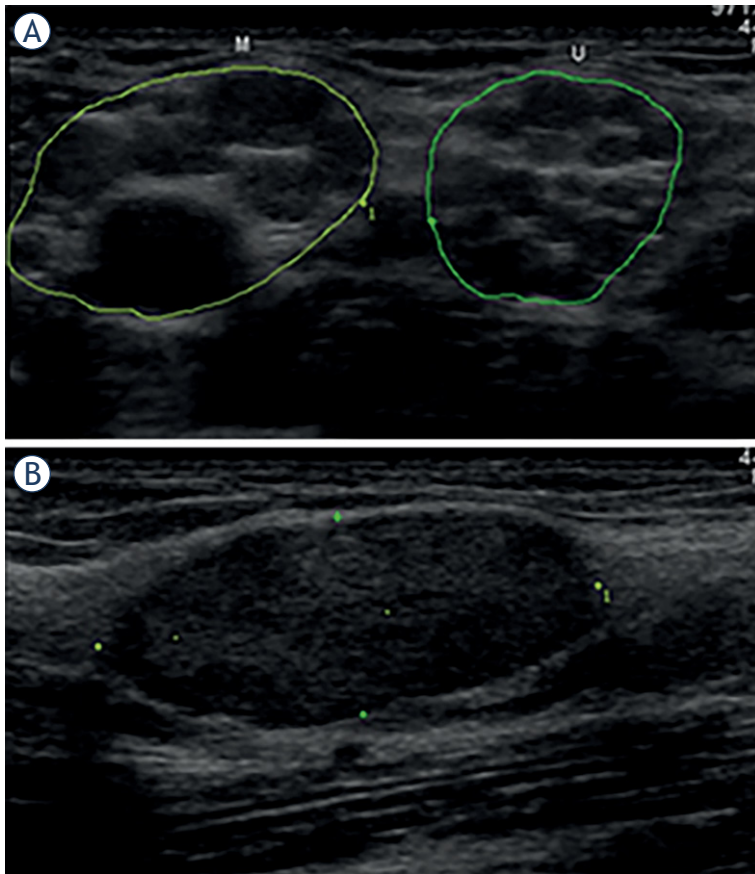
(A) Transverse ultrasonographic (US) view of the median (M) and ulnar (U) nerve in the axillary region showing numerous globular hypoechoic peripheral nerve tumours (PNTs) causing largely increased nerve cross sectional areas (CSAs, 148 mm² and 101 mm², respectively). (B) Longitudinal view of a single partially encapsulated, slightly lobulated and rather homogenous oval PNT (length 24 mm, thickness 9 mm) with central, but poorly defined nerve-tumour transition.⁵ Most probably these numerous PNTs are neurofibromas, although diagnosis in this 52-year-old woman presenting with peripheral neuropathy, primary lymphedema, and history of mitral and aortic valve surgery (patient #13, Tables 2–3), is not known yet.
